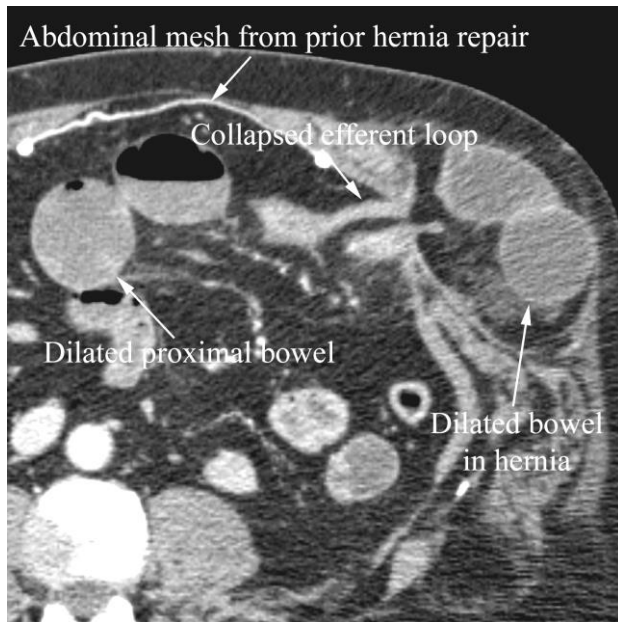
Small bowel obstruction from hernia in a 52 year old man with abdominal distension and a history of prior surgery. Axial CT shows dilated bowel loops proximal to and within the hernia, collapsed distal loops, and a transition point in the loop leading out of the hernia. Note the mesh in the anterior abdominal wall from prior hernia repair.
